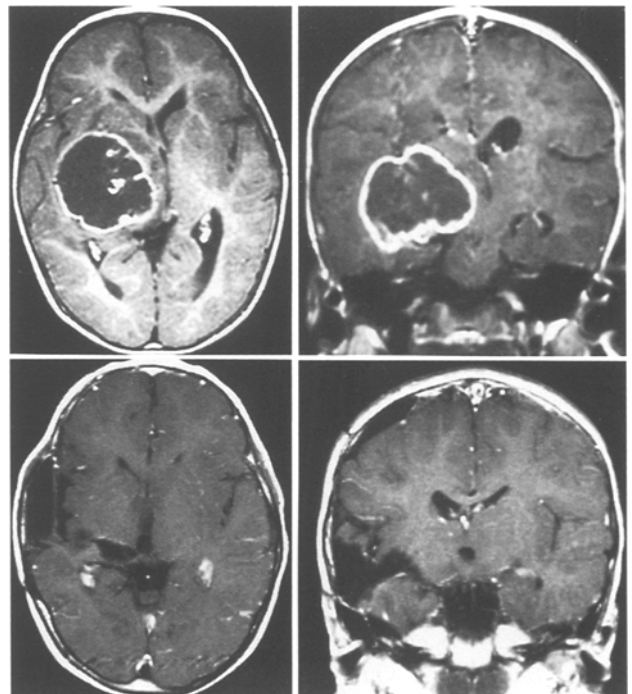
A 1-year-old boy with a 5-month history of progressive right-sided motor weakness and headache. MR images with Gd-DTPA show a large hypo-intensity mass with an irregularly enhanced rim in the left thalamus and basal ganglia (upper row). MR images with Gd-DTPA obtained 2 years after an extensive removal of the tumour show no evidence of tumour recurrence (lower row)
